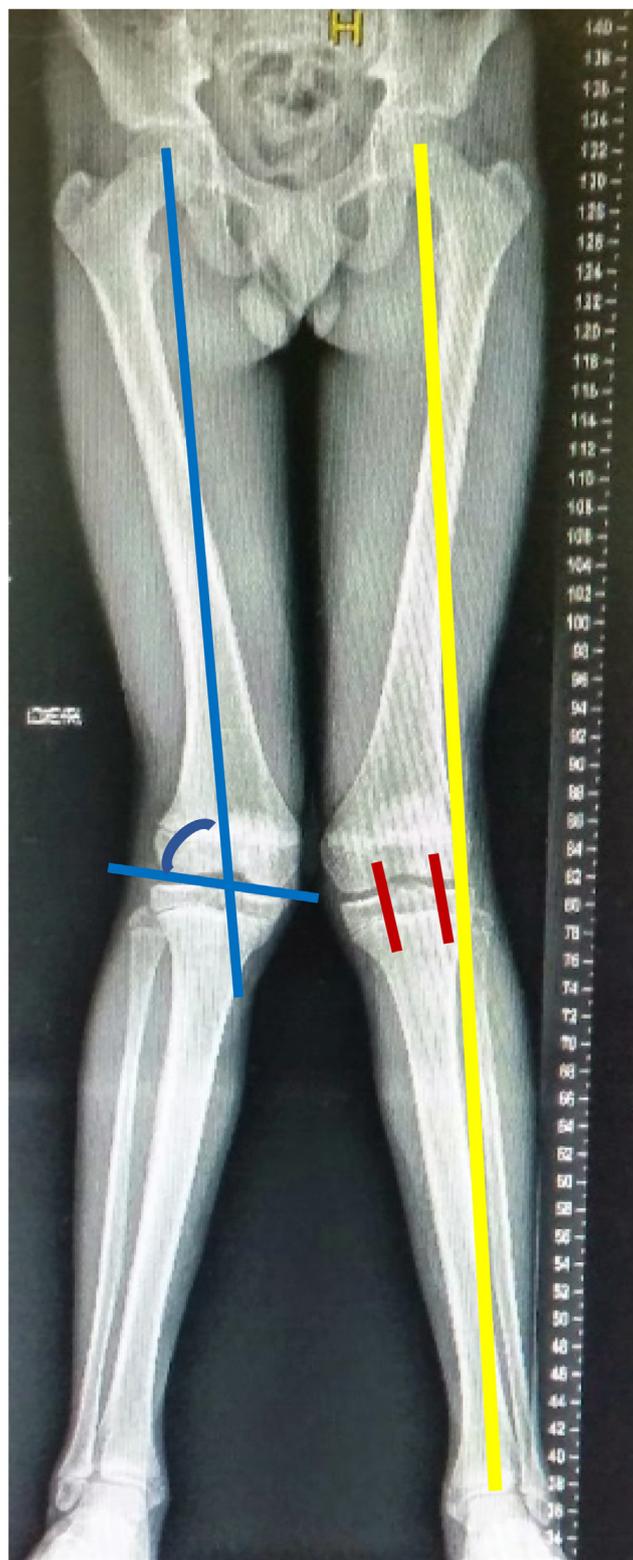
Radiographic measurement: mechanical axis in zone 2 (yellow). mLDFA (blue).
